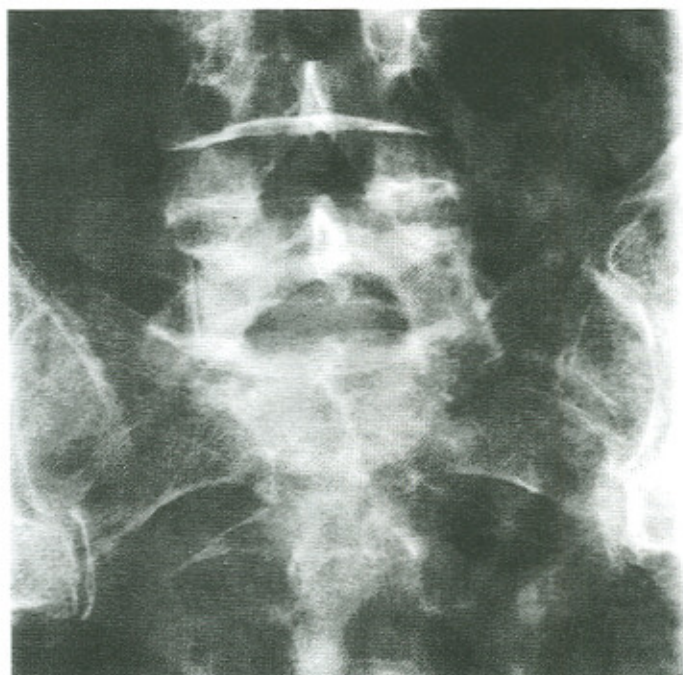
(a) Radiograph showing the SI joints of a 70-year-old female (case two) ten days after the onset of left sacroiliac joint pain. Note that both SI joints appear normal at this stage.
